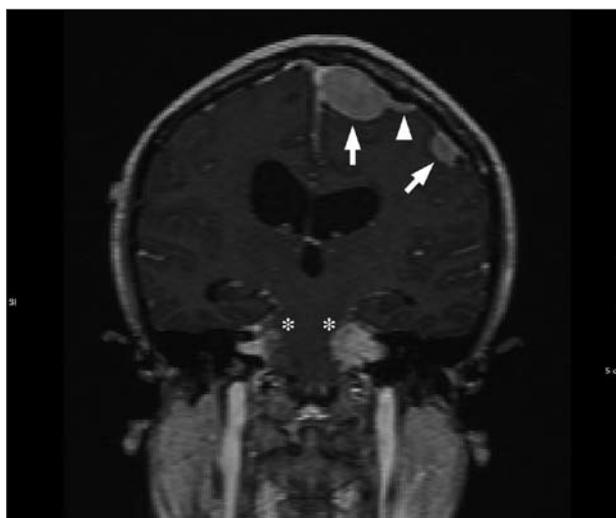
Typical magnetic resonance imaging features of neurofibromatosis 2. T1-weighted post-contrast coronal image showing multiple meningiomas (white arrows) with 'dural tail sign' (white arrowhead) and bilateral acoustic schwannomas (asterisks).
